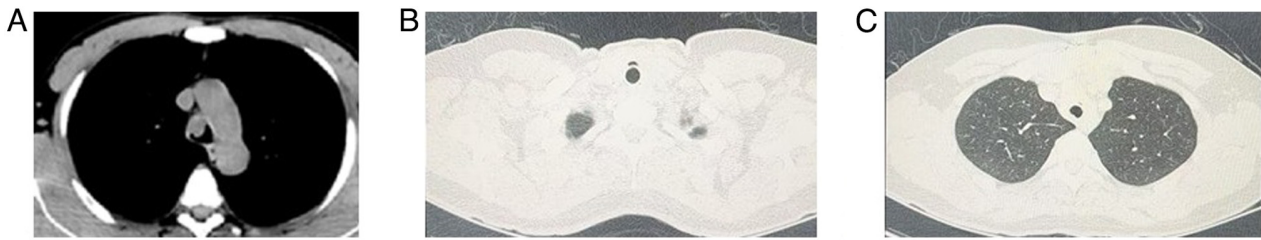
Tracheal adenoid cystic carcinoma. (A) CT scan of tracheal space-occupying lesion. (B and C) CT scan after silicone stent implantation. (B) CT scan showing the upper edge of the silicone stent after implantation. The silicone stent is closely attached to the trachea, and the image displays the condition of the upper part of the stent within the tracheal structure, with the stent fitting well in this region. (C) CT scan depicting the lower edge of the silicone stent post-implantation. The silicone stent is fitted closely to the trachea, and the image presents the condition of the lower part of the stent in relation to the trachea and surrounding lung tissue, indicating the position of the lower section of the stent. CT, computed tomography.
